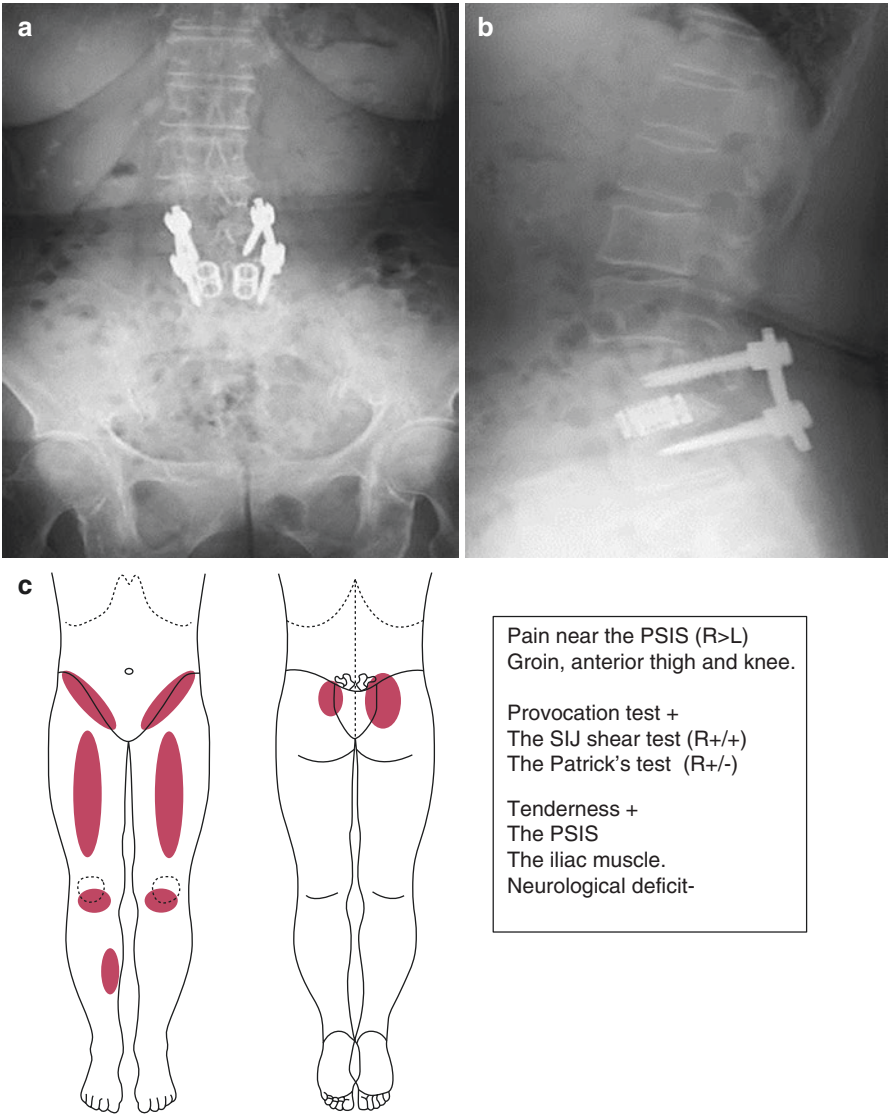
(a) AP view of lumbar spine on X-ray. (b) Lateral view of lumbar spine. (c) Painful area and physical findings. With permission from [1]
